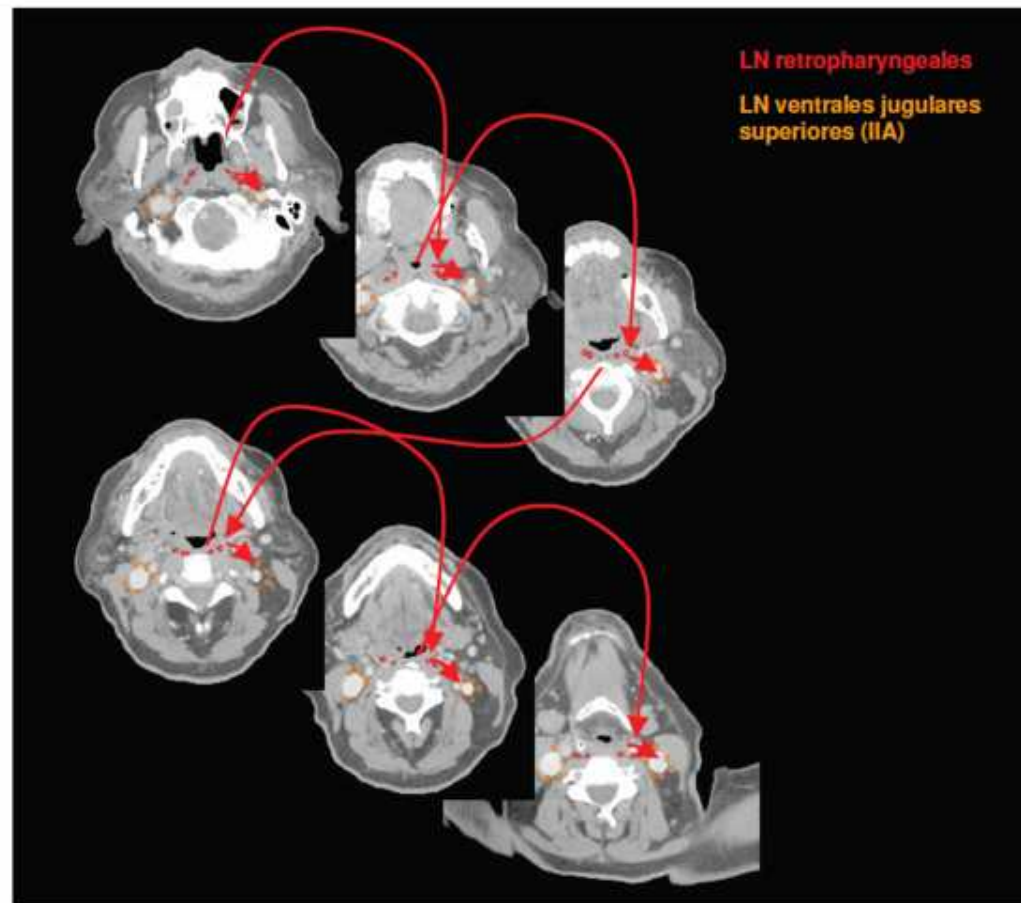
Lymph regions and drain contoured in transversal CT slices: LN retropharyngeales (red) [1 cm slice thickness].
